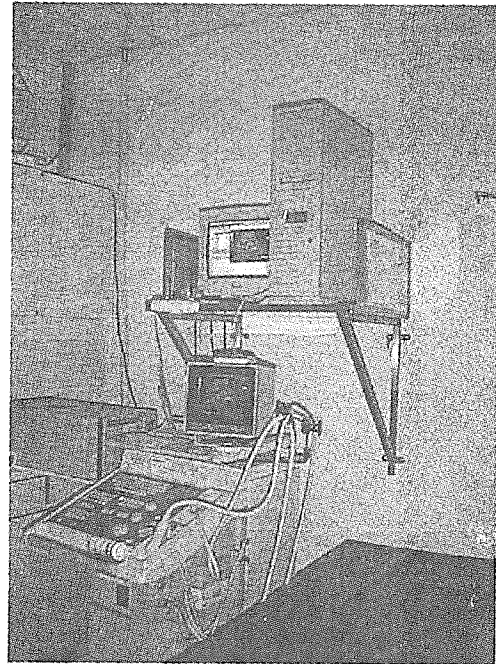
The image acquisition station of the UIAS (arrow) for the emergency ultrasound scanner.
